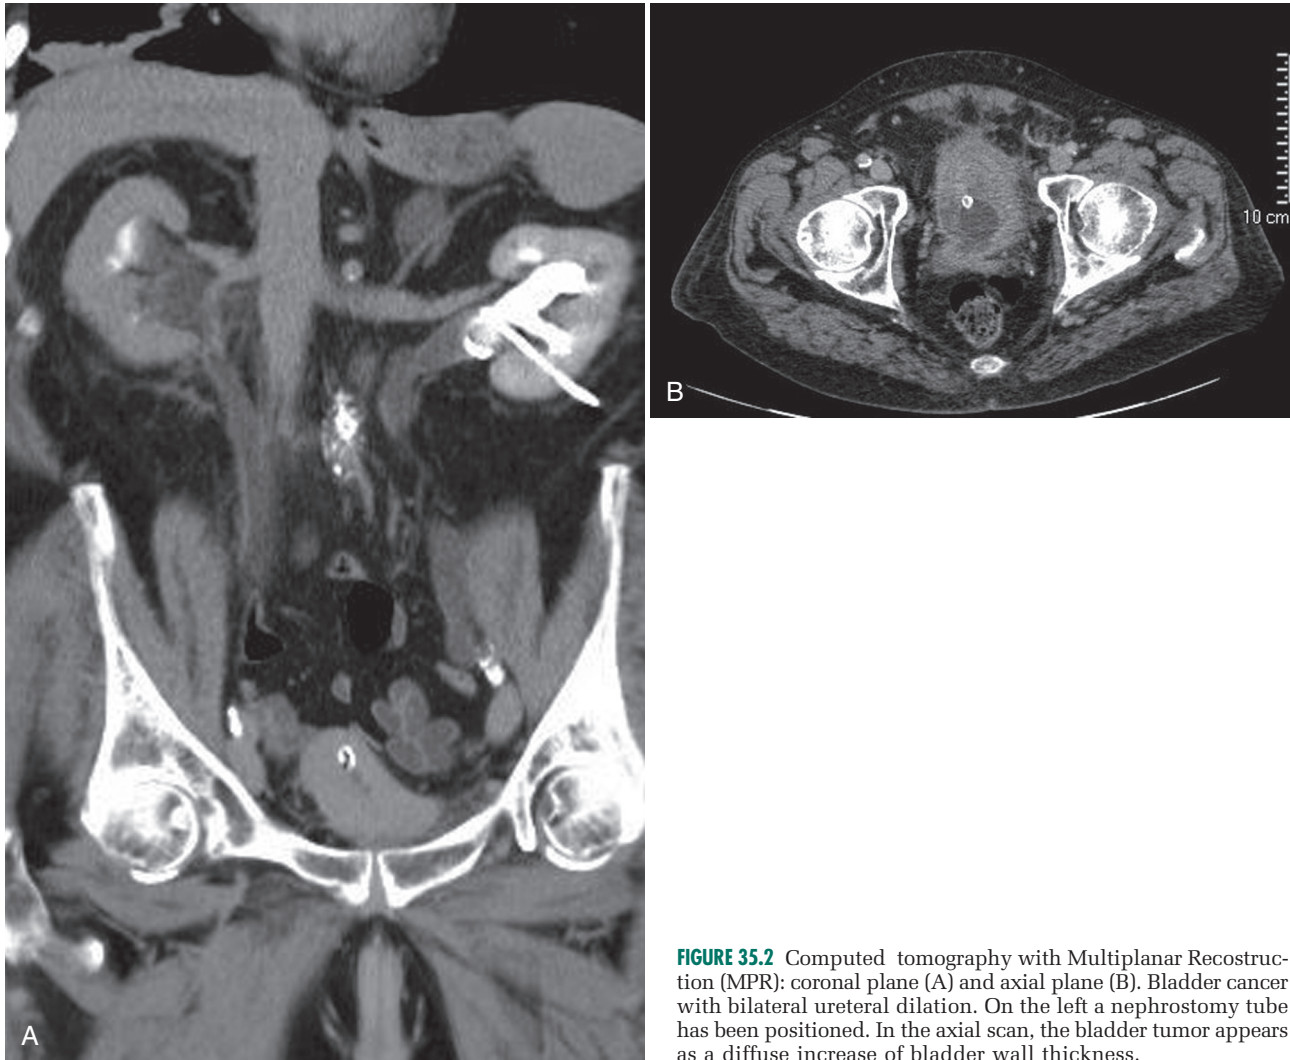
Computed tomography with Multiplanar Reconstruction (MPR): coronal plane (A) and axial plane (B). Bladder cancer with bilateral ureteral dilation. On the left a nephrostomy tube has been positioned. In the axial scan, the bladder tumor appears as a diffuse increase of bladder wall thickness.
